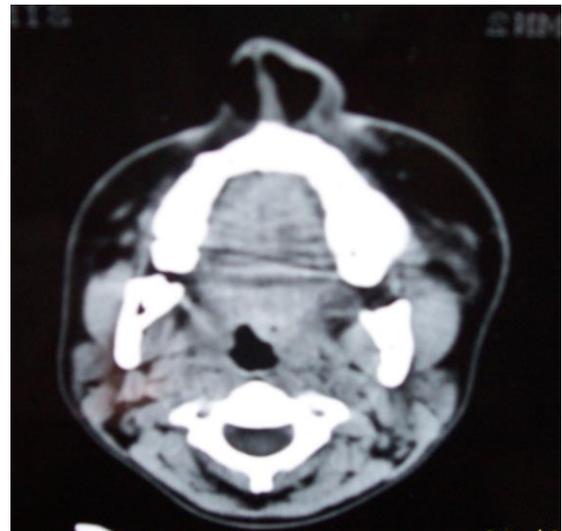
MRI revealing hyperplasia of right side
